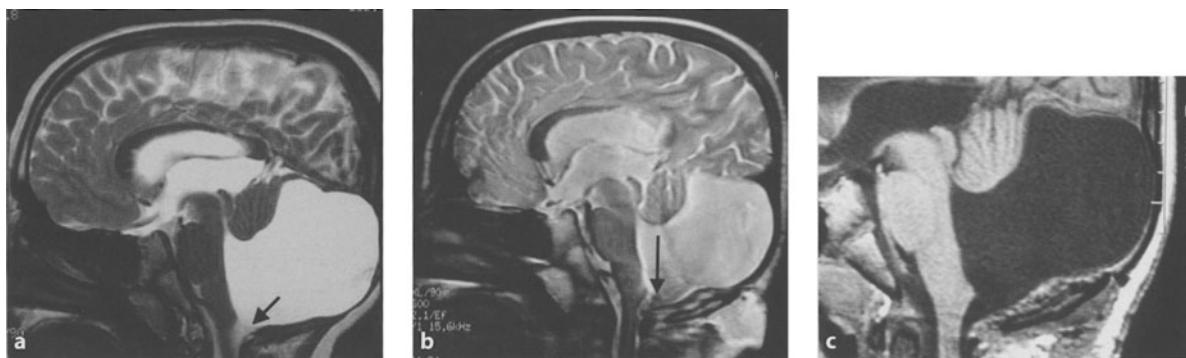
Ten-year-old boy with a ventriculoperitoneal shunt placed at birth, reoperated on several times for recurring shunt infection. Because of the large number of surgical procedures, microsurgical fenestration of the posterior fossa cyst was performed. a Preoperative MRI. b T2-weighted immediately postoperative MRI. Note the flow void at the level of the fenestration (arrow). c T1-weighted MRI 3 months after the fenestration. The patient is shunt-free
